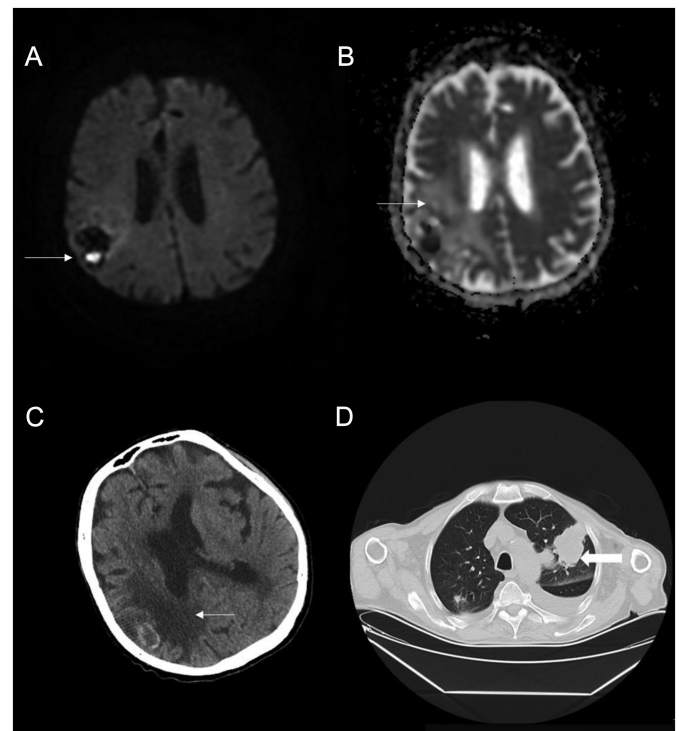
A 70-year-old man with intra-axial gray matter lesion in right parietal lobe. There's a focal diffusion restriction in the posterior aspect of the lesion (A, B) (arrows). Moderate perilesional vasogenic edema is seen (B, C) (arrows). Thorax CT reveals a large mass (arrow) in the upper lobe of left lung (D); pathology results confirm lung cancer in this patient. CT, computed tomography.
